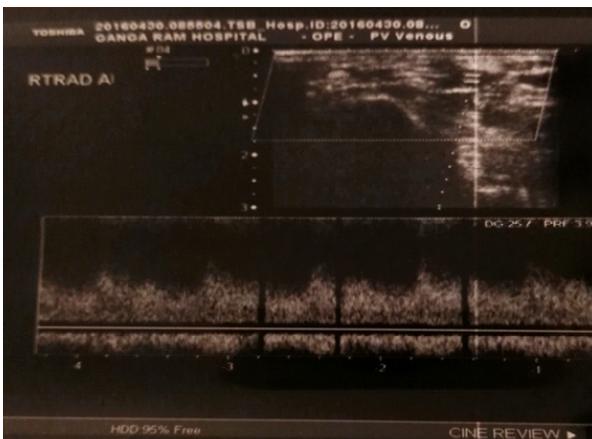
Radial artery Doppler showing continuous flow establishing AV communication
